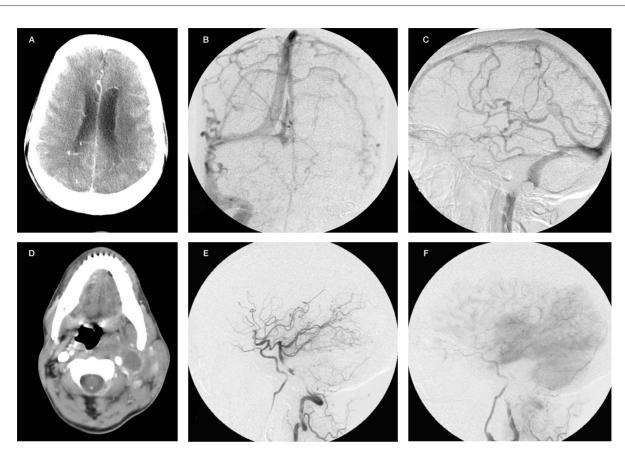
Contrast enhanced CT scans of the brain one month after the procedure revealed disappearance of the intracranial serpiginous veins (A). The venous sac at the vein of Labbe has also shown reduction in size. Venous phase of cerebral angiogram in frontal (B) and lateral (C) projections revealed normal caliber of intracranial veins. Contrast enhanced CT scan the level of the 2nd cervical vertebra revealed thrombosis of the jugular venous sac (D). Left vertebral angiogram (E and F) revealed persistent opacification of the fistula by retrograde flow. Flow within the fistula was extremely slow.
